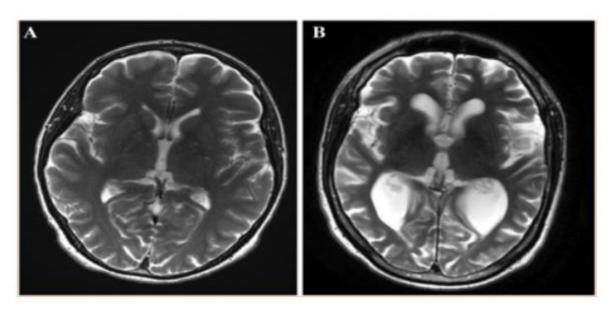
(a) MRI scan of AD; (b) MRI scan of normal brain
